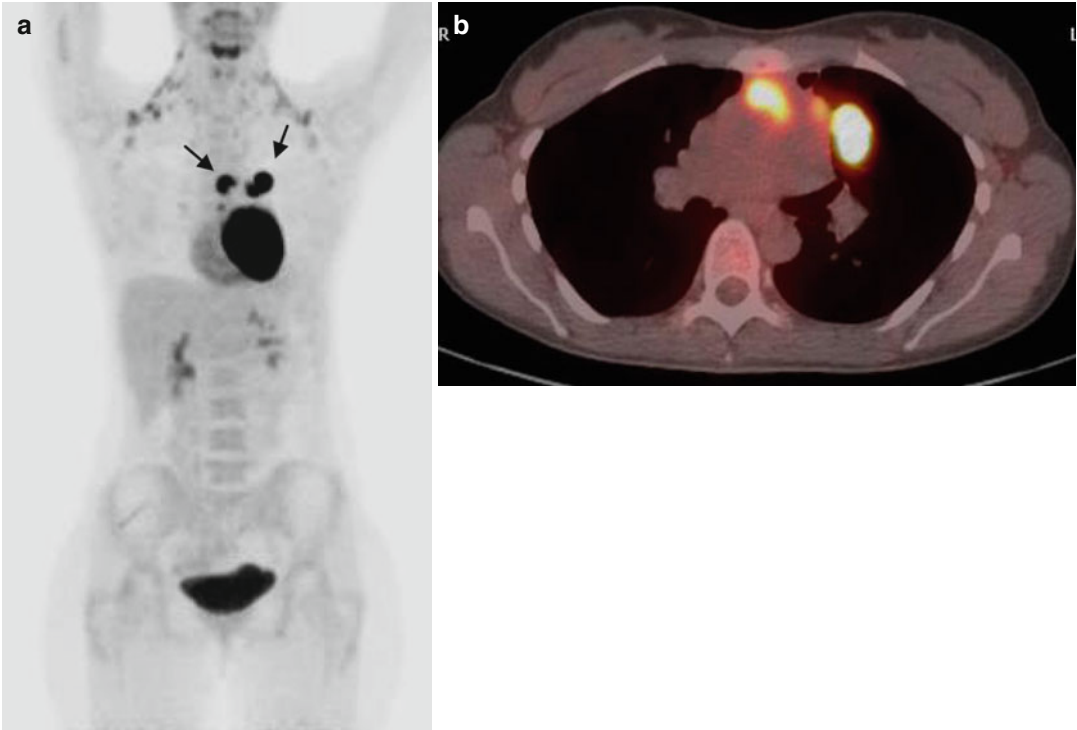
(a, b) MIP-PET and fused PET/CT after immunochemotherapy: Residual hypermetabolic mediastinal mass and hypermetabolic left lung nodule (*arrows* in the MIP image). Bilaterally increased 18FDG uptake in the neck corresponded to sites of activated brown fat
